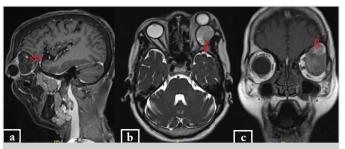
Preoperative contrast-enhanced magnetic resonance imaging depicting the cyst (red arrow). a) T1 sagittal, b) T2 axial, c) T2 coronal. A small region of T1 hyperintensity is seen within the posterosuperior aspect of the lesion, suggestive of probable blood within the cyst
